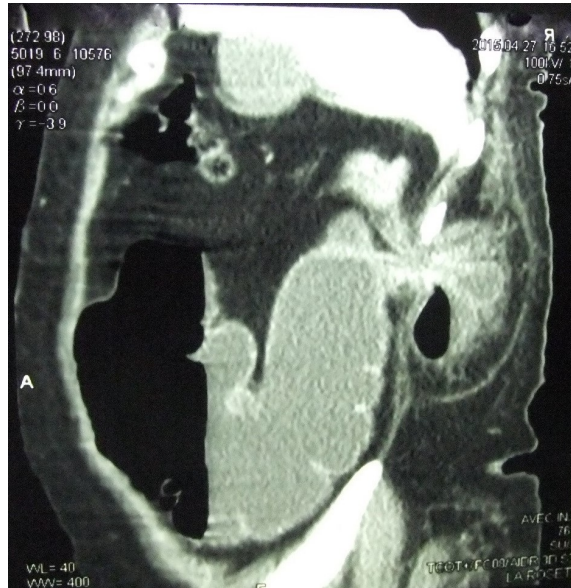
Longitudinal section CT of Grynfeldt hernia.
